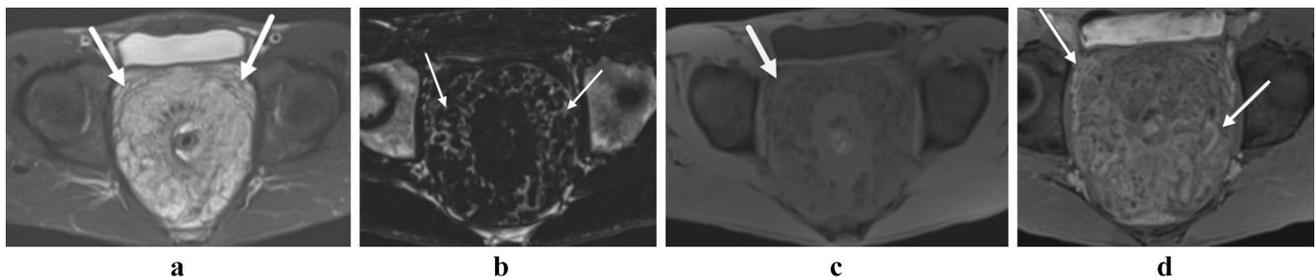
Rectal hemangioma. Axial T2-weighted fat-suppressed (a), Dixon fat-suppressed (b), pre-contrast T1-weighted fat-suppressed, and post-contrast T1-weighted fat-suppressed (d) MR images show
